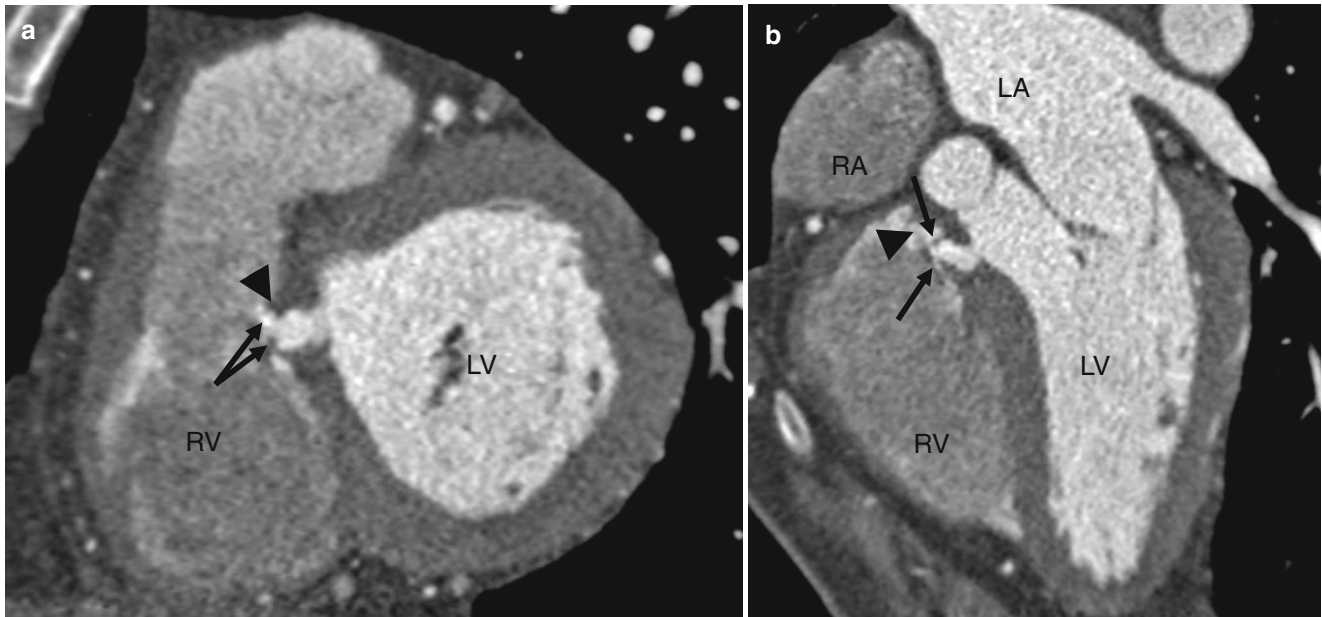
Closing type 2 VSD with tricuspid valve adherence. Panels (a, two-chamber view) and (b, four-chamber view) computed tomography scans showing a small ventricular septal defect (VSD) (black arrowheads) extending to the right side of the septum with the septal leaflet of the tricuspid valve (black arrows) adhering to
